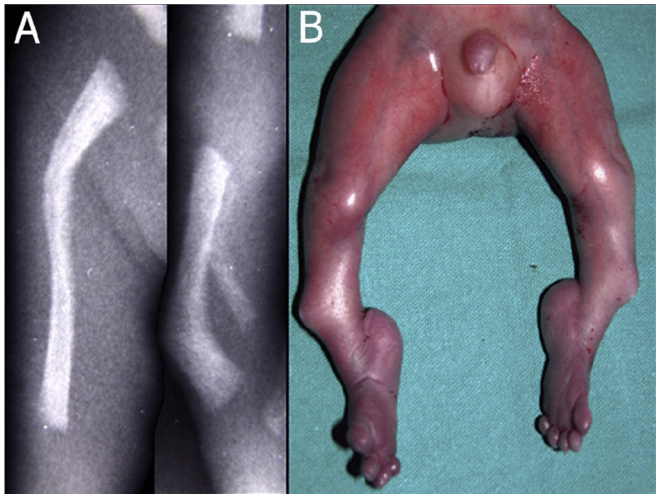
Case 1. (A) Radiograph and (B) *post mortem* details of the lower limb. Note confirmation of the severe bowing of the long tubular bones as identified by prenatal ultrasound. The *post mortem* confirmed clubfoot and spurs.
